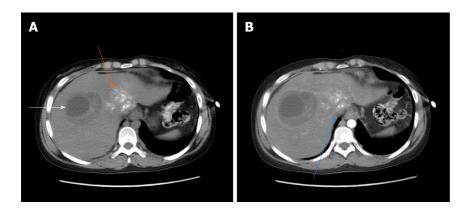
The second case of abdominal enhancement computed tomography. A: The low-density shadow indicated by the white arrow is a cystic hydatid lesion, while the high-density shadow indicated by the orange arrow is an alveolar hydatid lesion; B: The blue arrow indicates the retrohepatic inferior vena cava.
